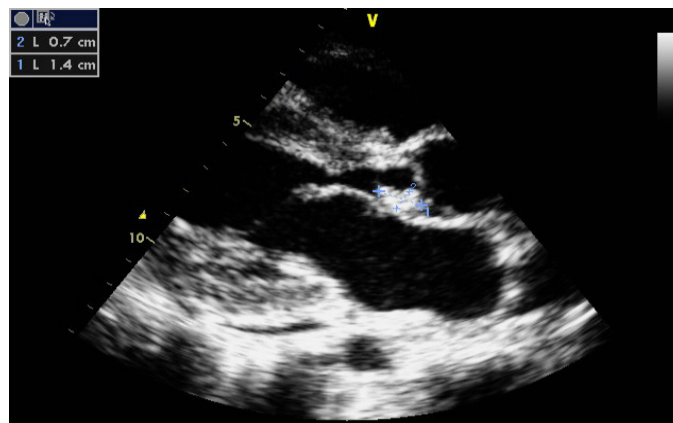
Anomalous echo in aortic valve, parasternal longitudinal axis.
